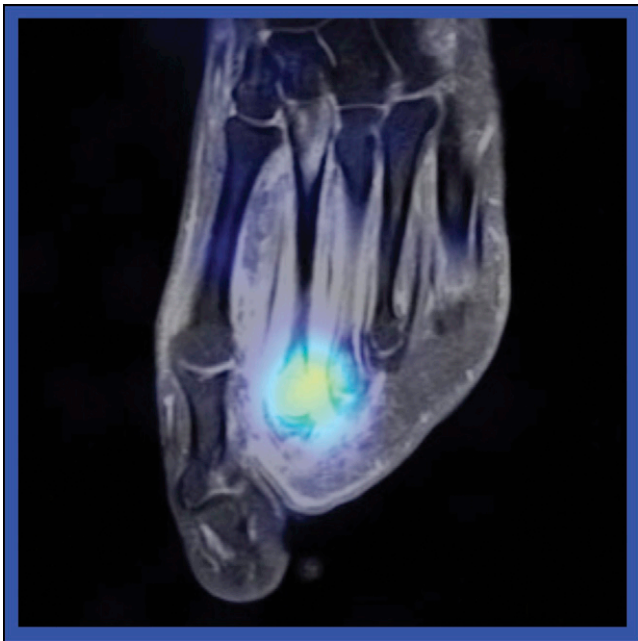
SPECT/MR Image of the Year. ^{111}In -white blood cell SPECT and MR imaging revealed osteomyelitis and soft tissue disease in this 24-y-old woman.
